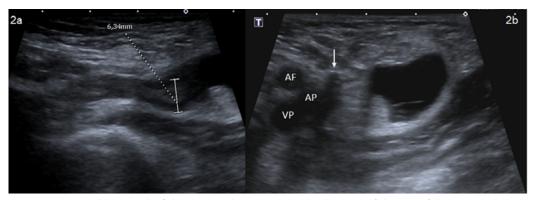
Ultrasound of the inguinal region. 2a) thickening of the tip of the appendix; 2b) fluid with thin septa inside the hernia sac.
